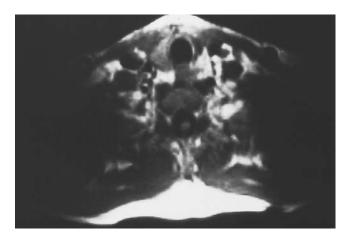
Magnetic resonance image of parathyroid mass.
